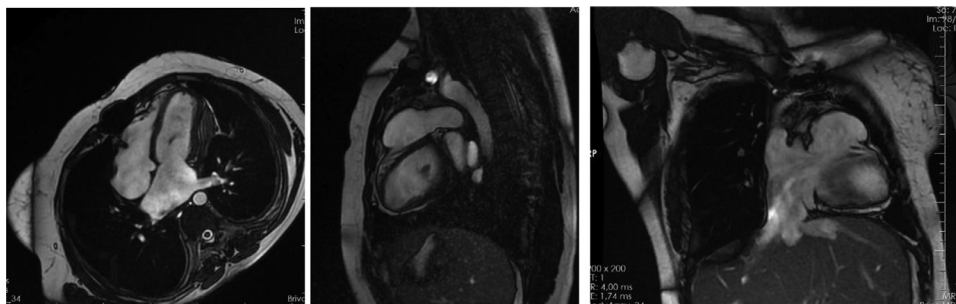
Dilatation of RVOT, pericardial thickening, and biatrial enlargement (MRI FIESTA axial, sagittal, coronal).
